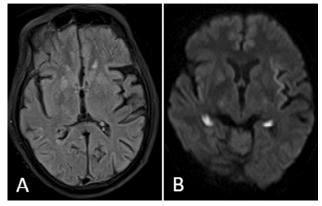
A 35-year-old male bought to the hospital with complaints of seizure, cerebrovascular accident, and unconsciousness for one day. The MRI scan demonstrates acute ischemic changes, which are (A) Axial FLAIR image reveals high signal intensities bilateral hippocampi, bilateral subcortical white matter show restricted diffusion on the diffusion-weighted image (B).
